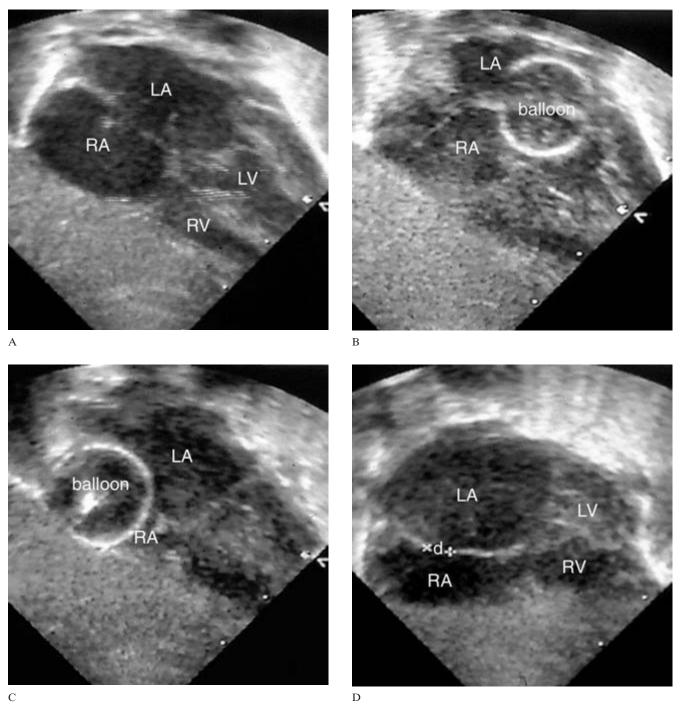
5 Echocardiograms showing Rashkind septostomy. A. Subcostal four-chamber view shows that atrial septum is intact. B. The venous catheter is introduced into the left atrium (LA) and the balloon is inflated. C. The balloon is pulled back into the right atrium (RA). D. After septostomy, a defect (d) is created. LV, left ventricle; RV, right ventricle.
